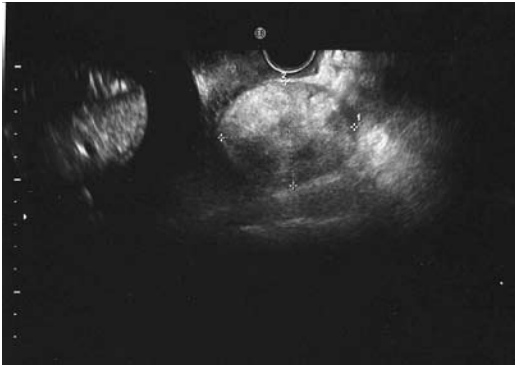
Ultrasound sonography of metastatic ovarian tumor
